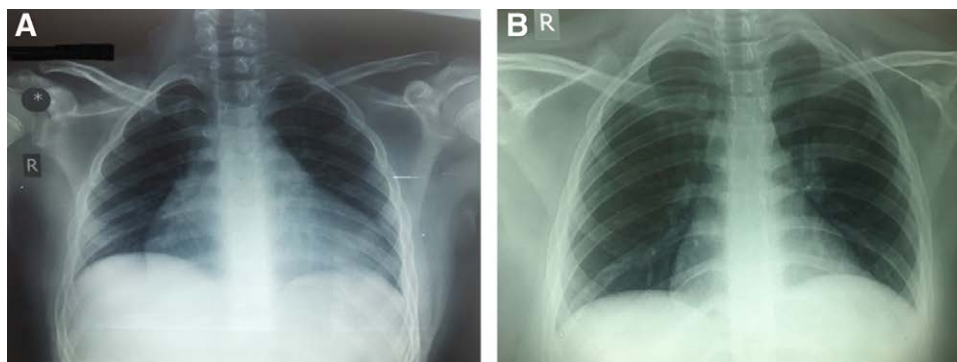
Chest radiograph demonstrating (A) the enlarged cardiac silhouette in case 1 and (B) normal chest radiograph in case 2.
